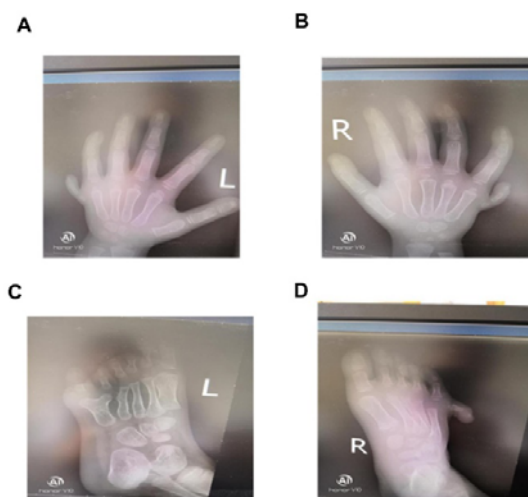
X-ray images of both hands and feet (left and right) of a child before surgery (A-B: left and right hands; C-D: left and right feet)
